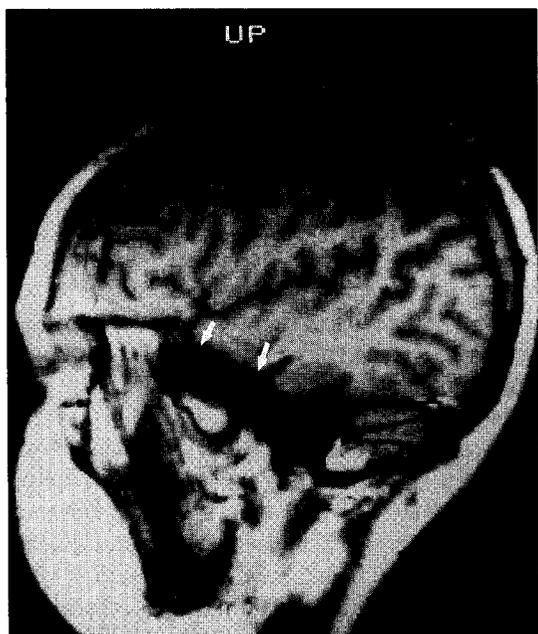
A lateral sagittal view magnetic resonance imaging (MRI) scan of the brain; arrows indicate the sectioned region of the anterior temporal lobe.
